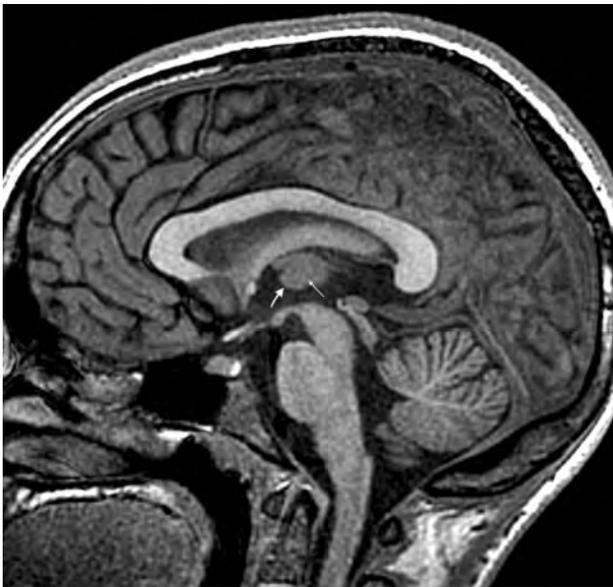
Sagittal midline T1WI from a brain MR imaging with normal findings in an 11-year-old girl with headache, showing a normal MI with part of its superior and posterior margin volume averaged with the medial thalami in a patient with a small third ventricle (*large arrow*). This appearance has the potential to compromise MI evaluation both qualitatively and quantitatively. However, a faint marginal distinction is often seen when carefully analyzed (*small arrow*).
